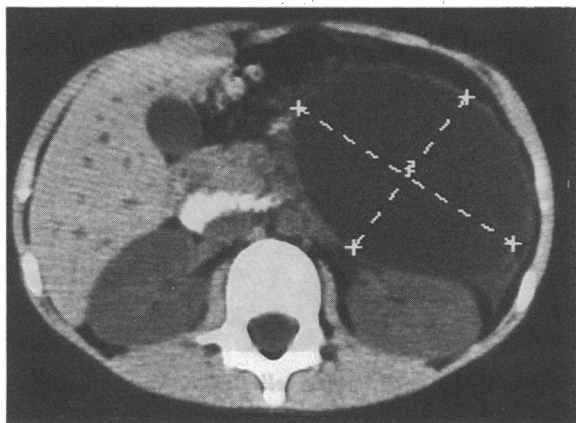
CT scan demonstrating a 10 × 7 cm cystic mass arising from the tail of the pancreas
